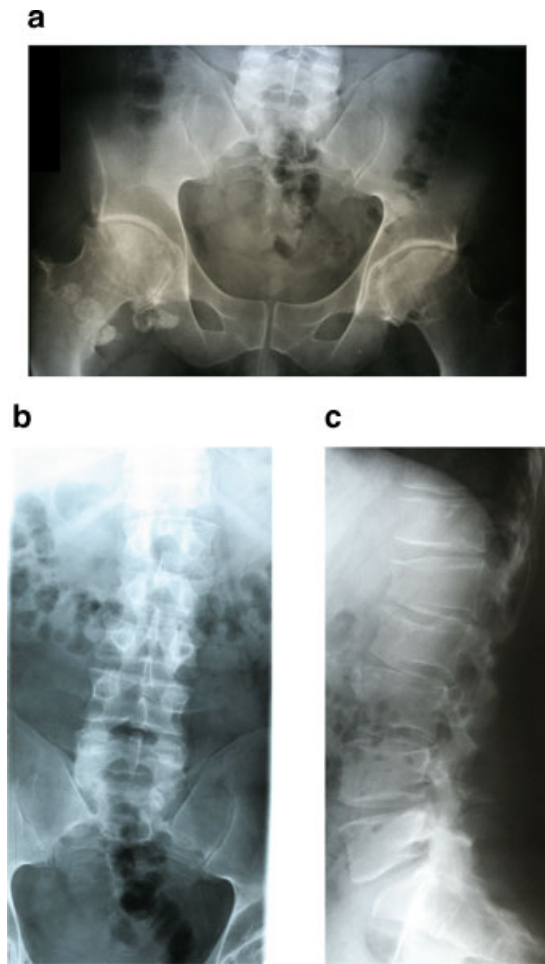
Radiographs of patient III-5: (a) Note: Arthritic changes of the hip joints and osteochondromatosis lesions (age 25 years). (b + c) Note: Mild platyspondyly and irregular shape of vertebral bodies.
